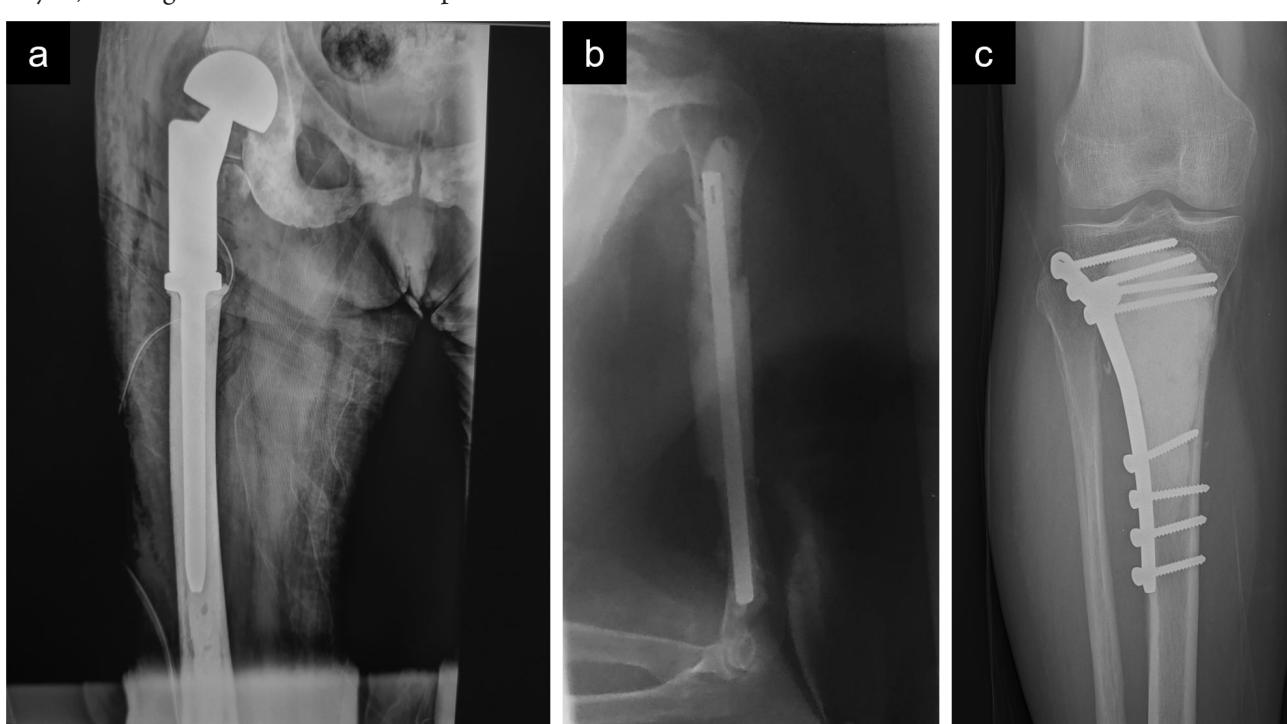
Postoperative X-ray showing different methods of surgical treatment: a) Resection of proximal femur with megaprosthesis arthroplasty – breast cancer SM; b) Intramedullary stabilization with cementing of humerus – lung cancer SM; c) Plate and screws stabilization with cementing of proximal tibia – melanoma SM
